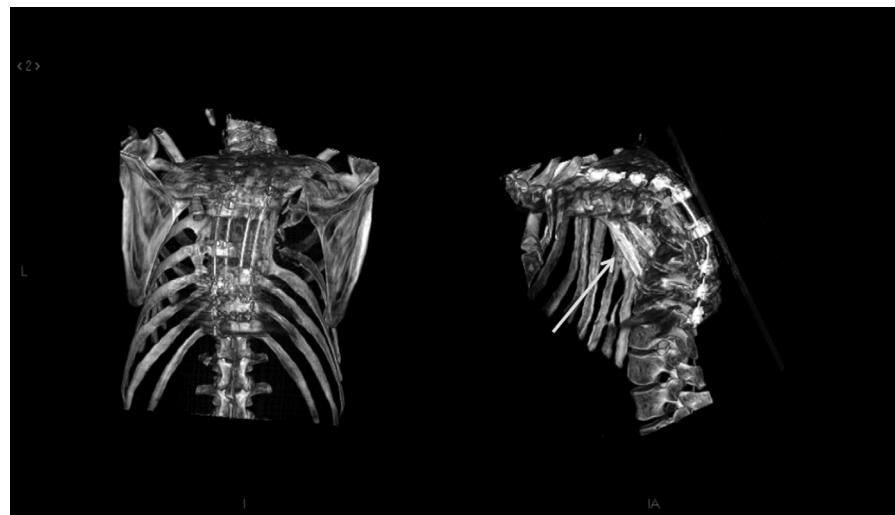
3-D thoracolumbar spine CT scan (Left), posterolateral instrumented kyphoscoliosis (Right), and anterior strut graft (white arrow).
